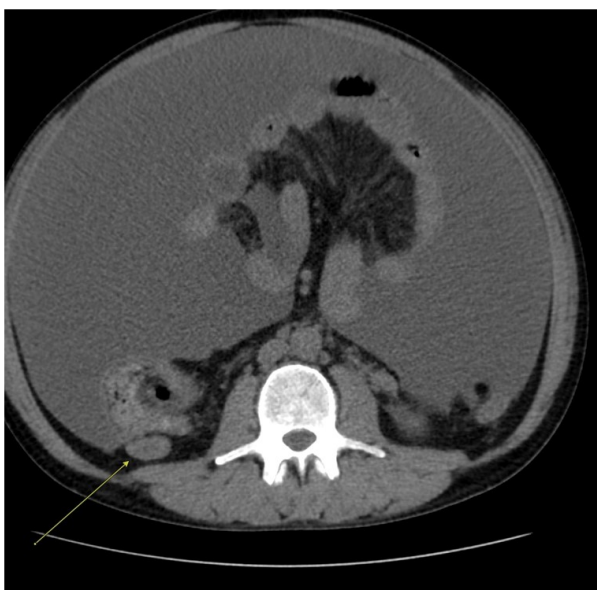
A retroperitoneal lymph node measuring 2.4 cm seen on the initial CT scan Abdomen Pelvis.
